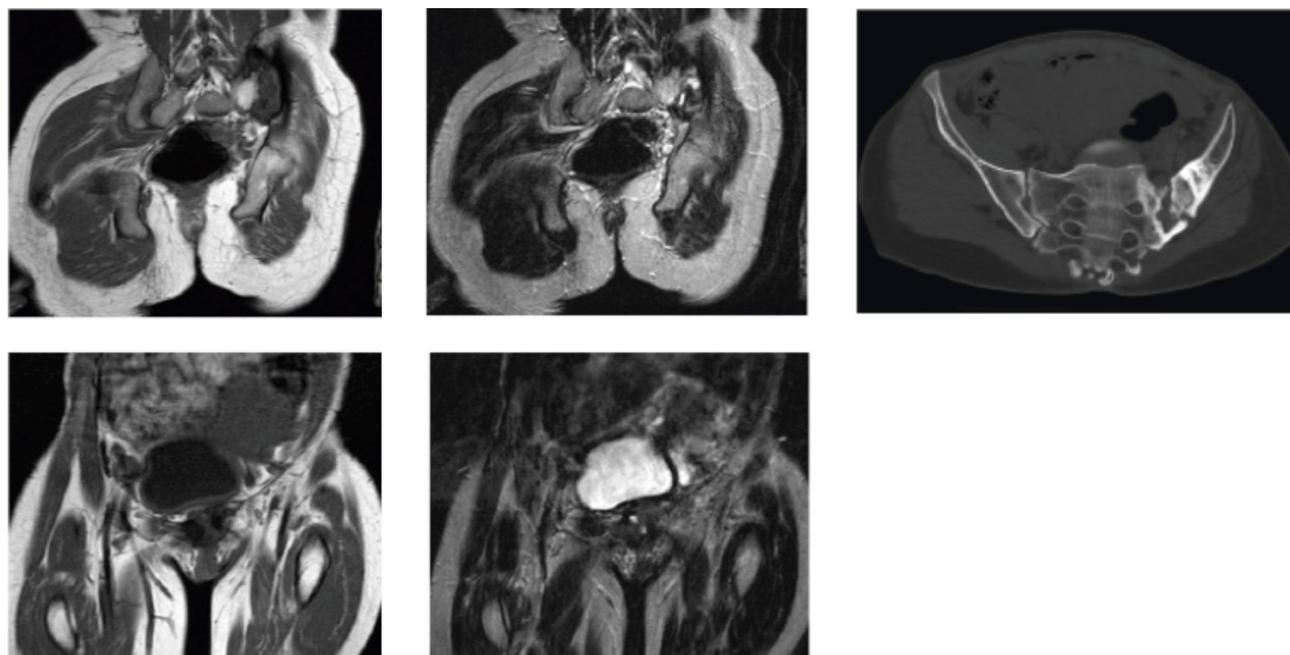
Candida* arthritis. MRI images in T1 (left) and T2 (centre) showing bone marrow lesions around the left sacro-iliac joint and pubic symphysis (hypointense in T1, intermediate signal in T2), suggesting 2 infectious foci. Right: transverse view showing destruction of the joint's edges, with thickening of the joint space and consolidation of surrounding tissues.
